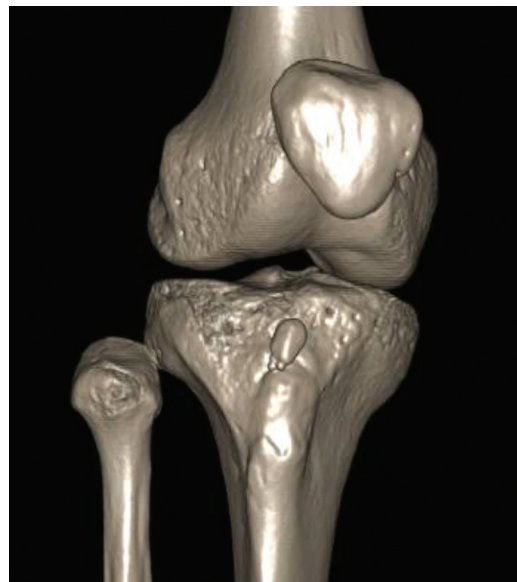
Frontal view of 3-D reconstruction of a CT scan confirming the luxation of the proximal tibiofibular joint in the right knee that had been suspected in the X-ray.
